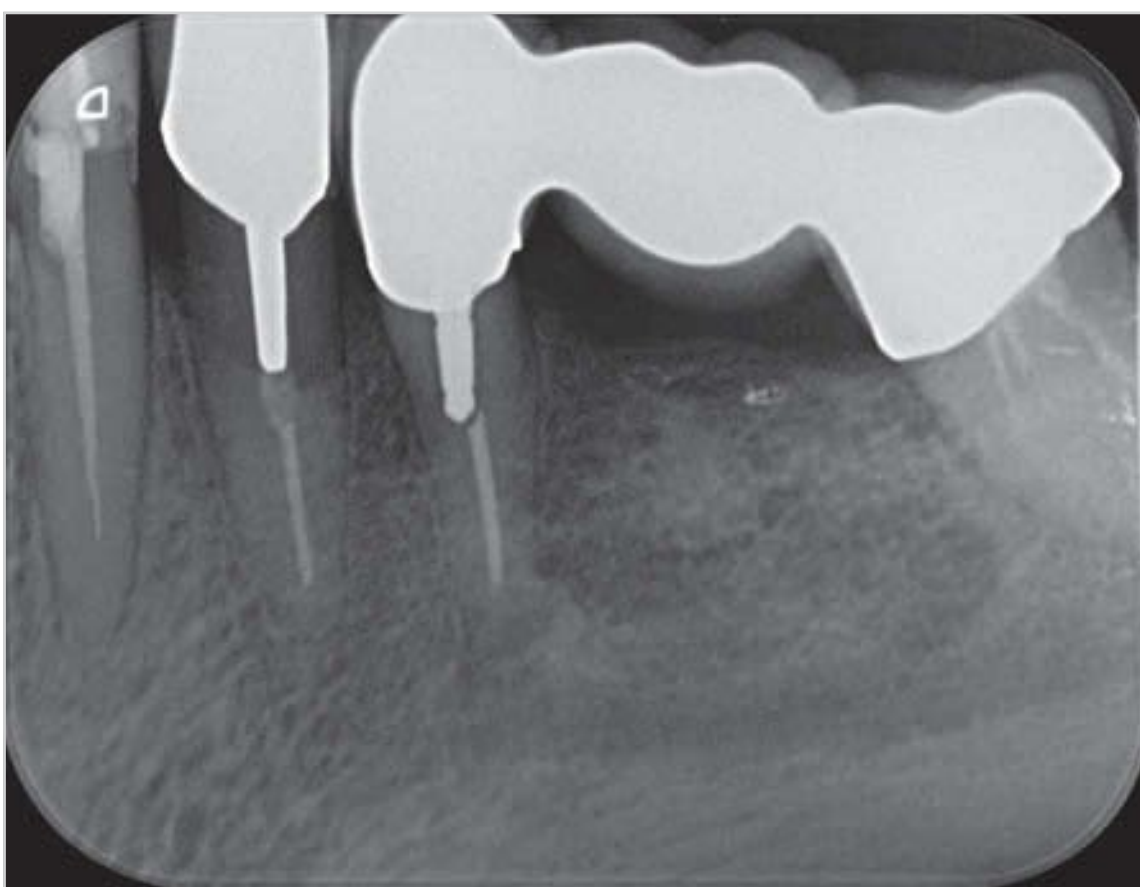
Dental X-ray film.
